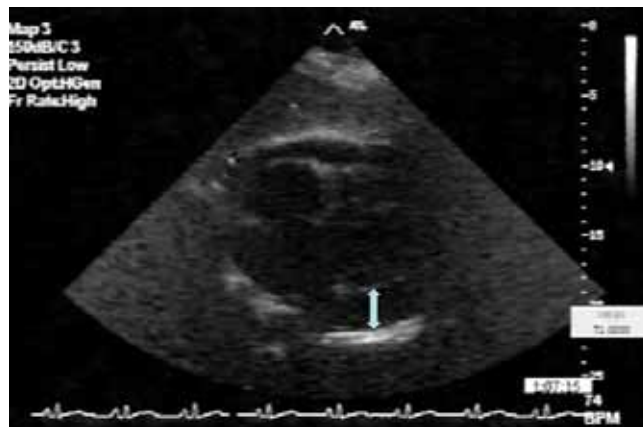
Repeat echocardiogram confirming large pericardial effusion (arrowed).
